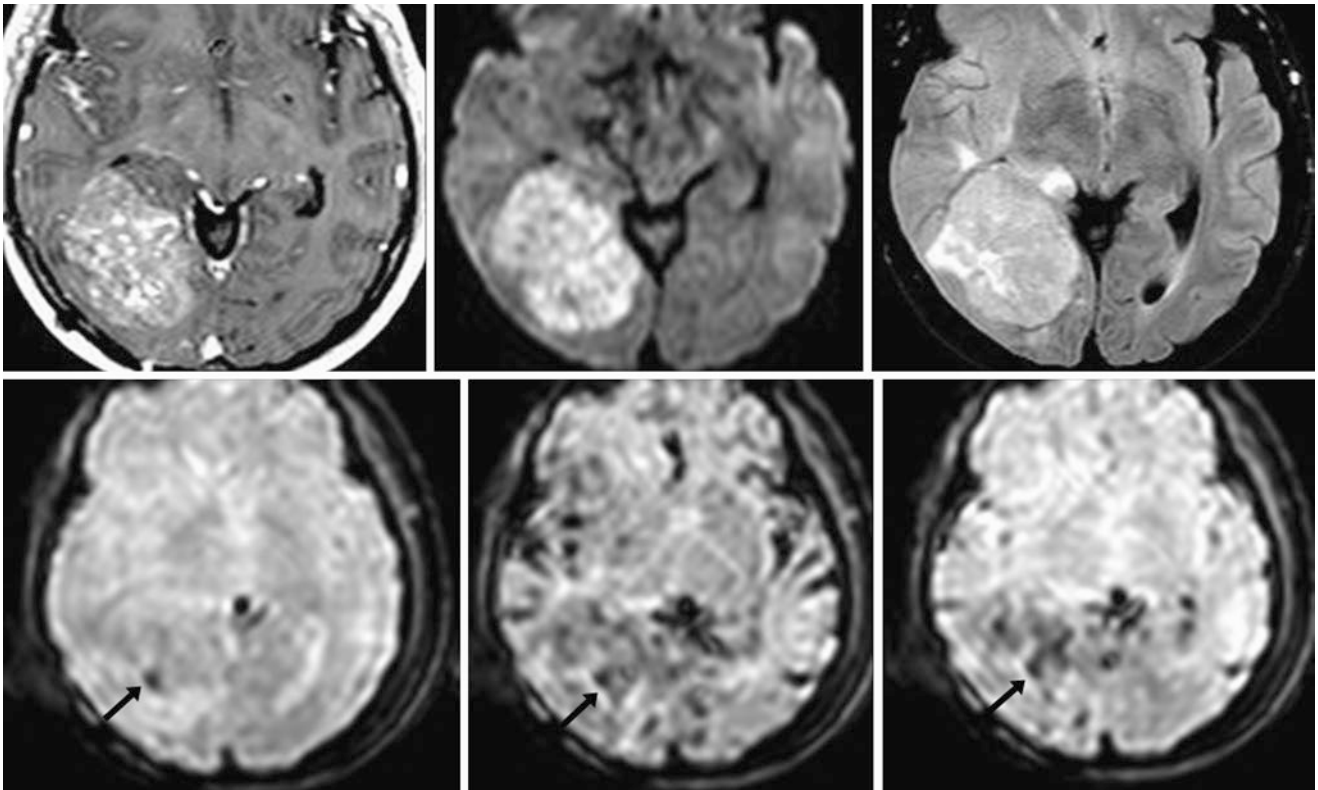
Comparison case of anaplastic oligastrocytoma. A 39 year old with a mass adjacent to and compressing the atrium of the right lateral ventricle on MRI postcontrast T1WI (*top left*), DWI (*top middle*, the reduced diffusivity is suggestive of malignancy), and noncontrast FLAIR (*top right*). The *bottom row* images are dynamic MR perfusion
